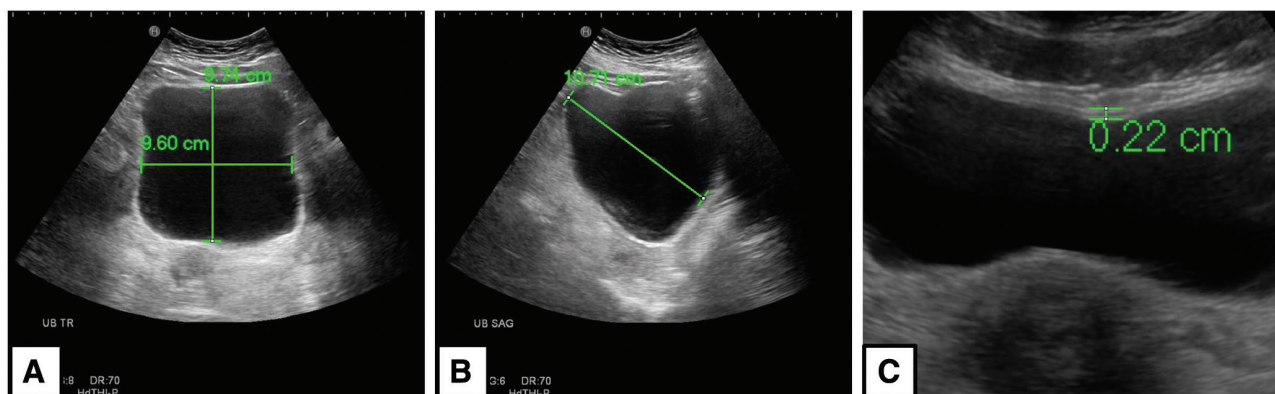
Measurement of bladder volume and BWT under ultrasound. A, The length and width of the bladder were measured from the transverse view; the length was defined as the greatest antero-posterior measurement; the width was defined as the greatest transverse measurement. B, The height of bladder was measured from the mid-sagittal view; the height was defined as the greatest superior-inferior measurement. C, The bladder wall thickness was measured at the anterior bladder wall.
